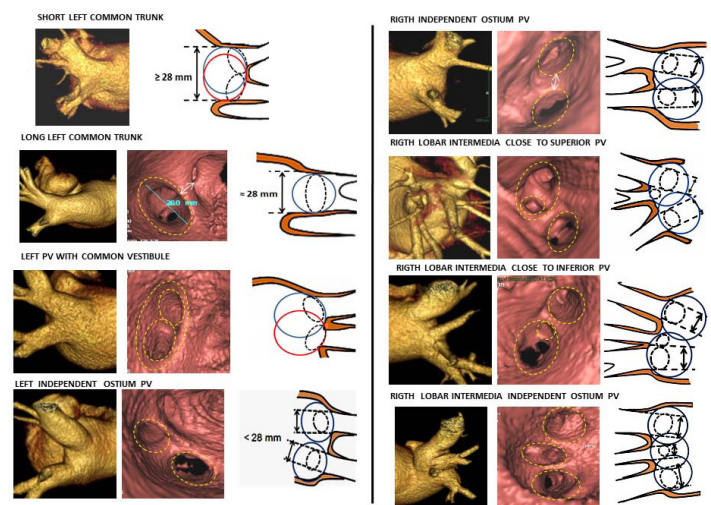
Endoluminal and CT Scan reconstruction anatomical approach, to assess diameter/ shape and sizes of PV/LA-PV junction level and interpulmonary ridge, in relation to the size of CB to be used and the orientation for better PV-LA wedging
